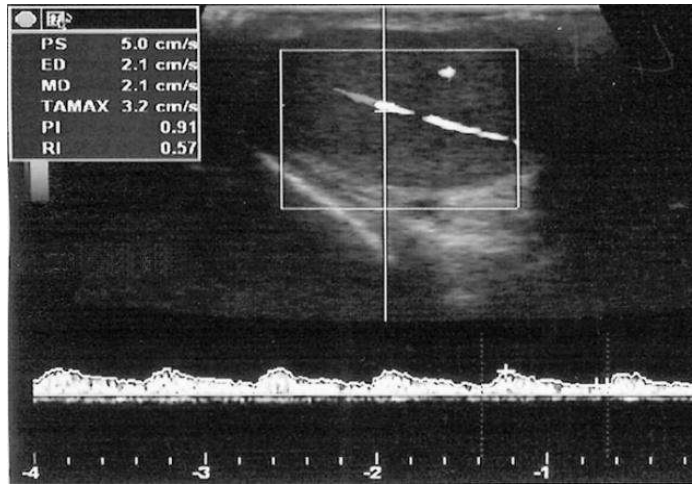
Transverse Doppler ultrasound image shows RI and PI measurement in intratesticular artery in a 32 year-old patient.
